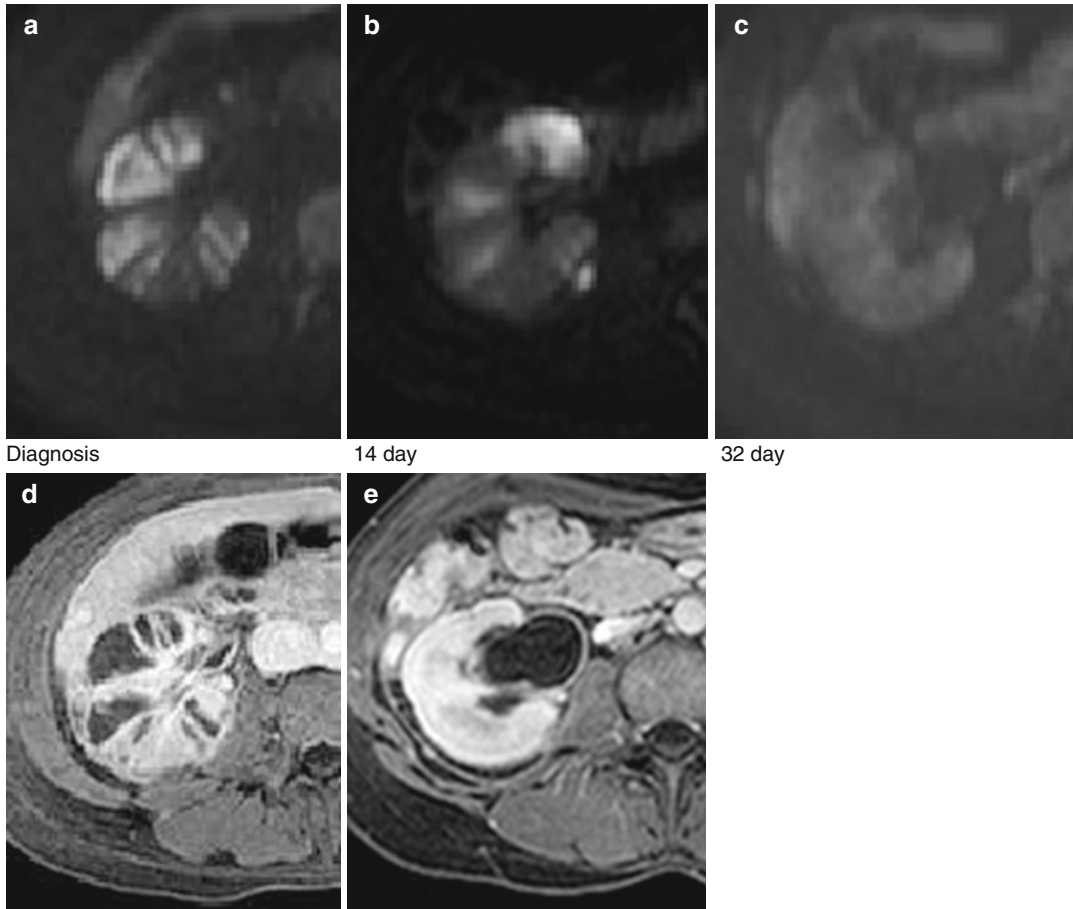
DWI targeted on the right kidney with $b=1,000$ (c) in patient with a history of pyelonephritis arising after childbirth; at diagnosis (a) multiple areas of intense signal restriction are visible, referring to multiple abscesses and ischemic parenchyma, which correspond to
